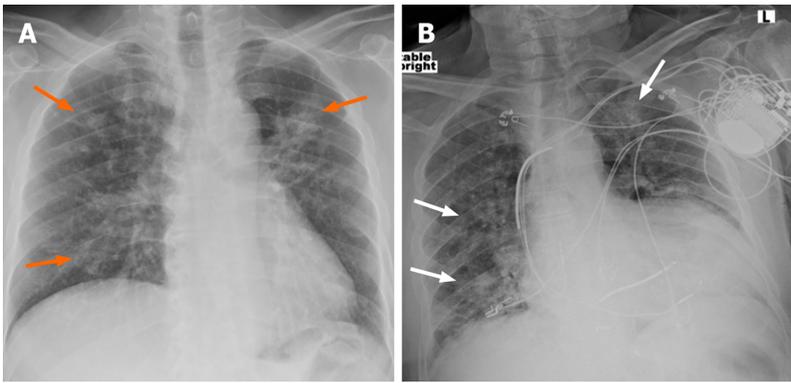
Chest radiography. A: A 57 year old male with coronavirus disease 2019 (COVID-19) infection shows multifocal bilateral air-space opacities (orange arrows) in both lungs; B: Another 74 years old male came with cough and dyspnoea in emergency department shows hazy airspace opacities in both lung parenchymas (white arrows) who later turned out to be positive for COVID-19. A left chest wall AICD device is also seen.
